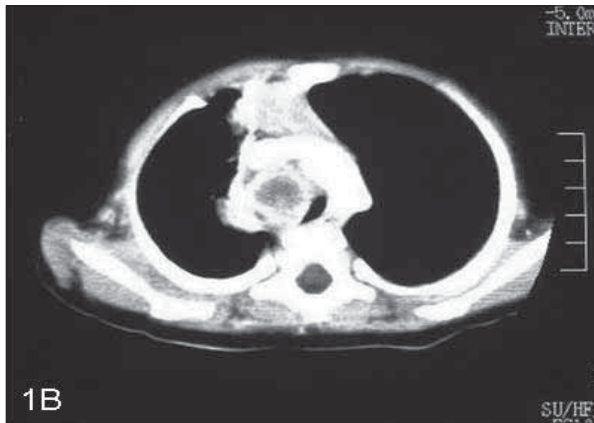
Computed tomography (CT) scan of the patient at admission
